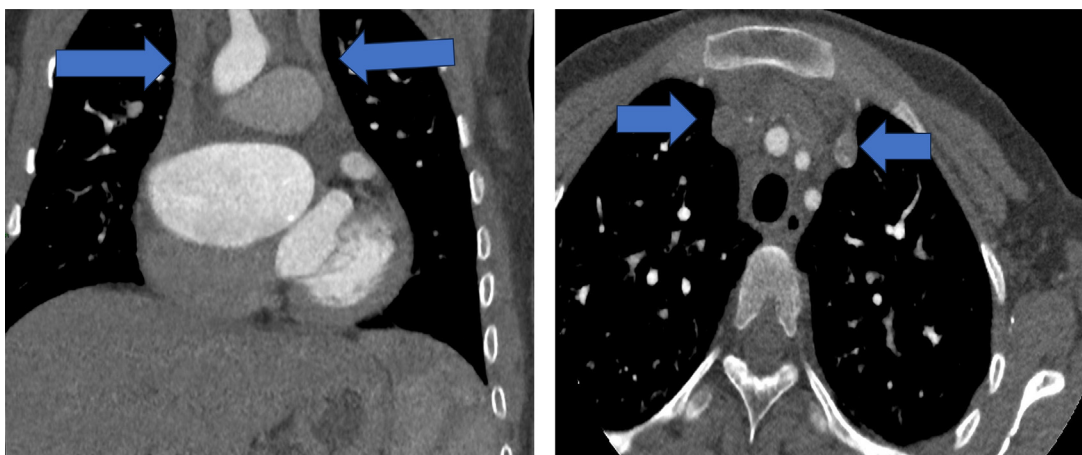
Two images of cardiac CT scans, axial and coronal views, show superior vena cava duplication (arrows).
